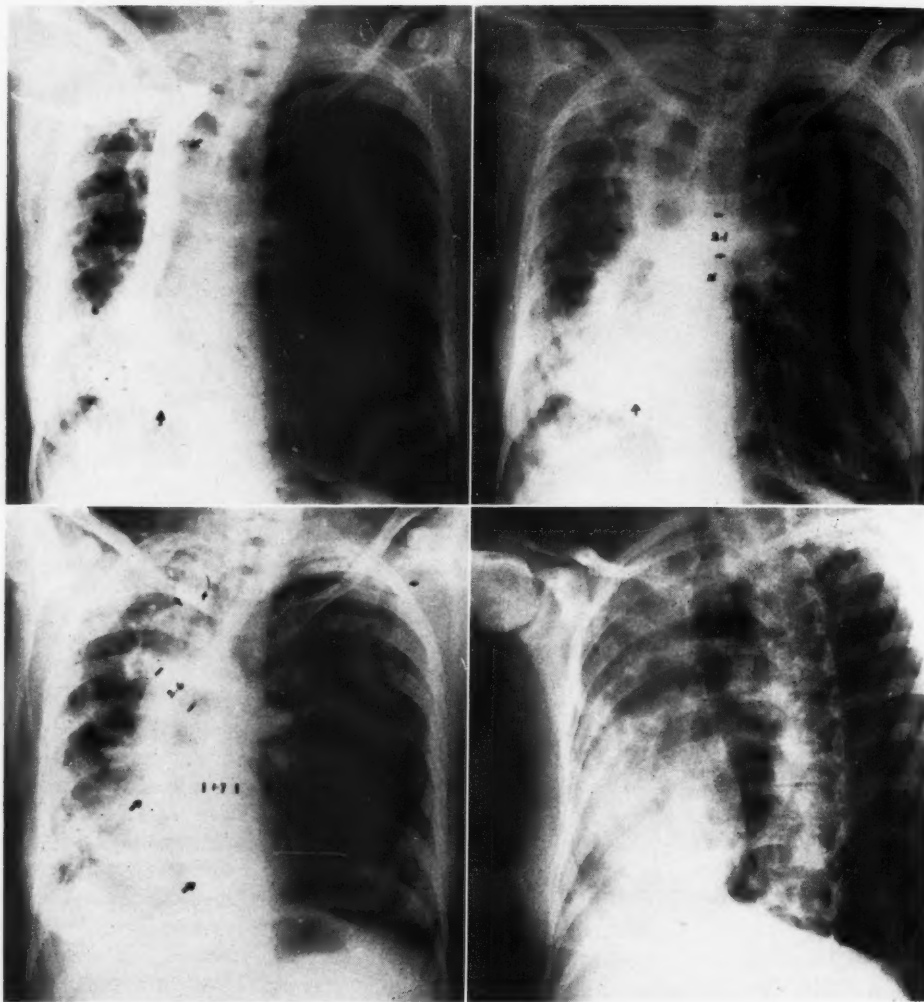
(*upper left*). Contrast roentgenogram, frontal view. Note kinking of the right subclavian vein and displacement of innominate vein and superior vena cava. The right auricle (denoted by darts) is beginning to fill. The upper left arrow indicates junction of innominate veins; lower left arrow, auriculo-ventricular groove.
